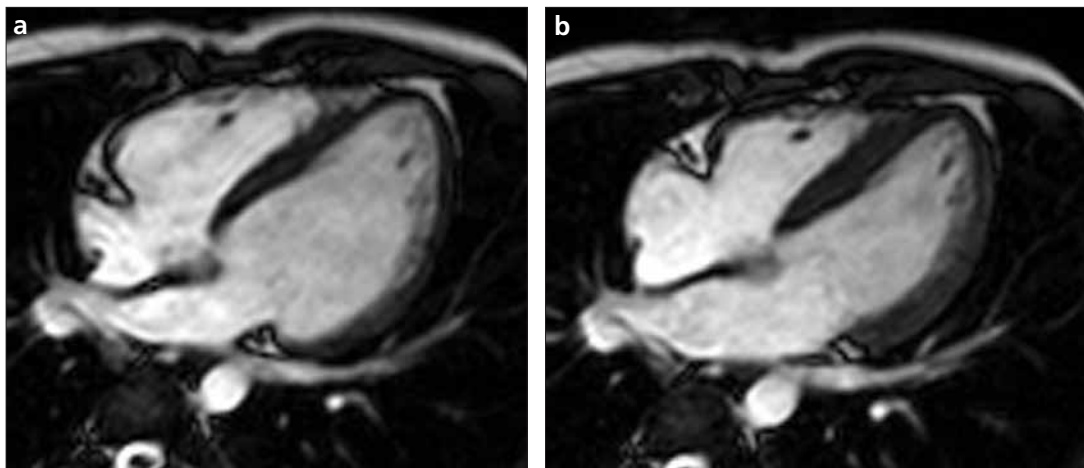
a, b. Horizontal long axis multi-segmented cine MR images taken during the end-diastolic phase (a) and the end-systolic phase (b).
